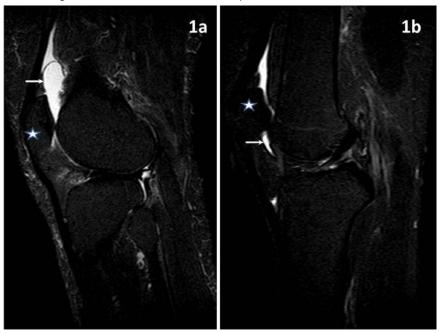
Fig 1a shows Suprapatellar bursitis in 46 Year old male with pain in the anterior aspect of knee, MRI STIR sagittal image showing fluid intensity lesion. Figure 1b. shows the collection in the deep infrapatellar bursa as well. Patella is marked with a star.
